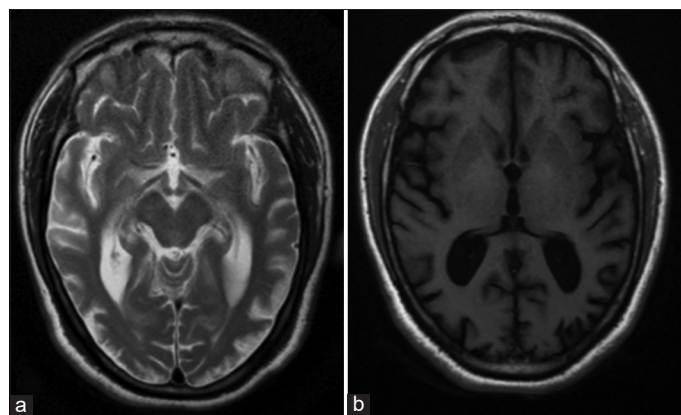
Repeat magnetic resonance imaging after 04 months reveals thinning of cortex (b) of the bilateral temporal and occipital lobes with T2 hyperintensity (a) consistent with encephalomalacia and gliosis
